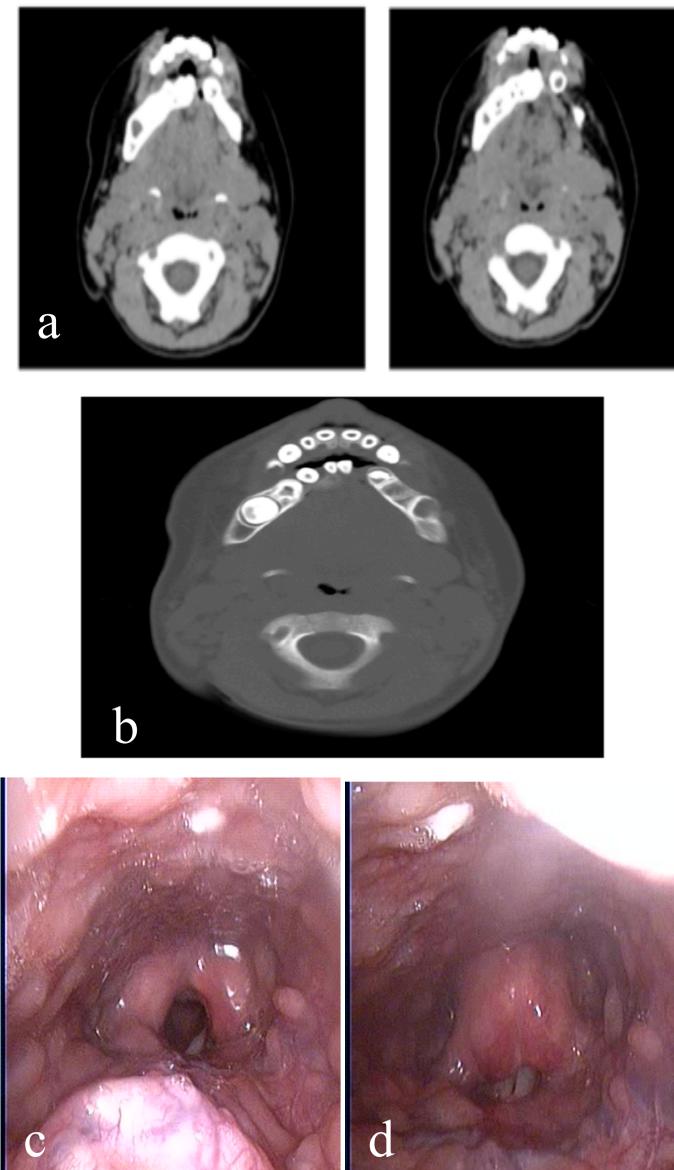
FIGURE a-b Axial CT images of the maxillofacial in soft tissue and bone windows displaying bilateral greater cornua and congenital absence of the hyoid bone.
